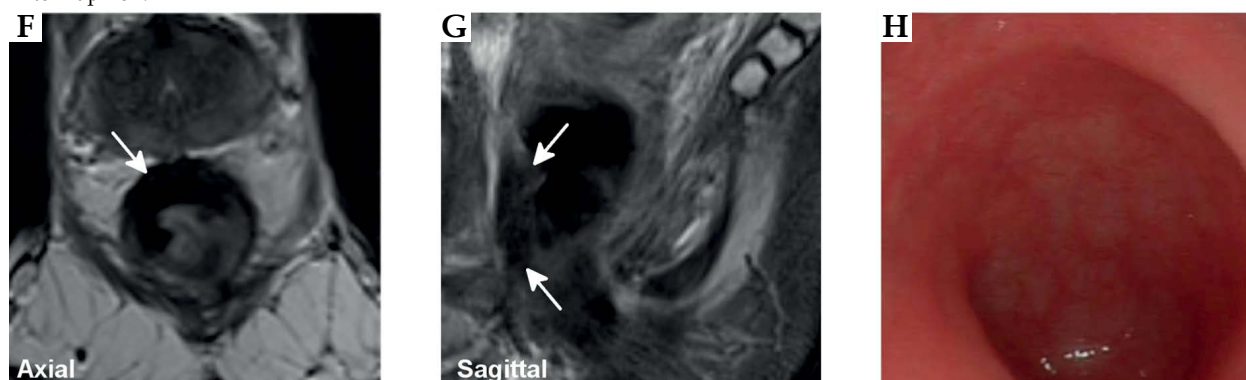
At presentation there is a semiannular anorectal junction tumor with 12 mm of mesorectal extension, staged T3C N0 (arrows, A-C). Six weeks after completion of an external beam radiotherapy course, the tumor has regressed with low signal fibrosis now present and no residual tumor bulk (arrows, D, E). There is significant high signal mucosal thickening noted in the rectal wall in keeping with the recent radiotherapy (arrowhead, D). A Papillon boost was then given. Magnetic resonance images from 12 months later (arrows, F, G) demonstrate maturing fibrosis, becoming blacker, and resolution of the mucosal edema, whilst only a radiation scar is seen on endoscopy (H). There was no palpable abnormality on digital rectal examination
